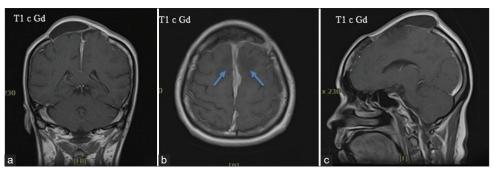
(a-c) Postoperative T1WI c gadolinium-enhanced MRI shows some residual tumor at falx cerebri. (b) The hypointensity area at the superior frontal gyrus around SMA (blue arrow) could cause akinetic mutism.
